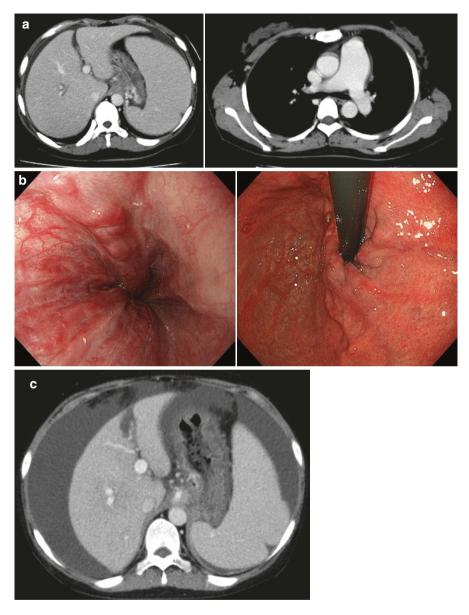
(a) Abdominal CT detected portal vein and splenic vein dilations and megalosplenia, but no NHR or ascites were found. A varix was found in the gastric wall, and pulmonary artery dilation was also observed. (b) EGD showed esophageal varices (LmF1CbRC1) and gastric varices (Lg-c F1 RC0). (c) After 2 years, abdominal-enhanced computed tomography revealed advanced atrophy of the liver and intensified ascites
